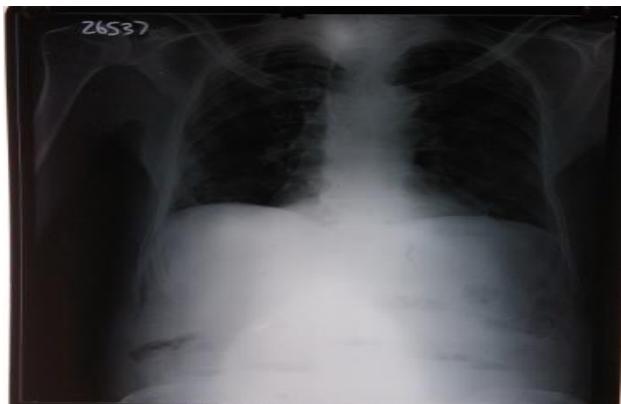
X-Ray abdomen erect showing few air fluid level in lower abdomen but no gas under diaphragm.
